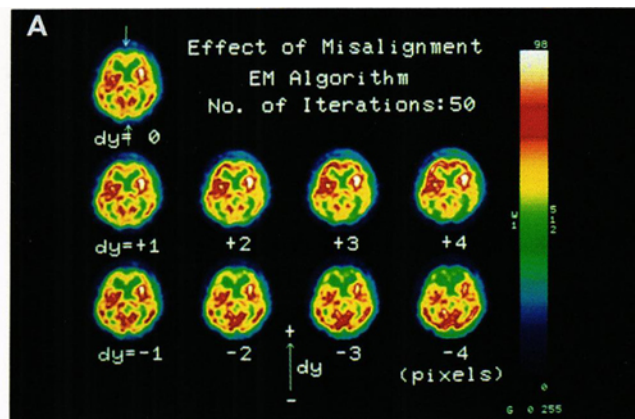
(A) Reconstructed SPECT images as a function of vertical shift (dy) in the clinical study. The numbers show the vertical shift in pixels. (B) Changes in image profile due to misalignment in the vertical direction. Position of the profile is shown by arrows in the upper left image in (A). The effect of a vertical shift (dy) of 0, +2, and -2 pixels is shown. — : $dy = 0$ pixels, ---- : $dy = +2$ pixels, and - - - : $dy = -2$ pixels.
